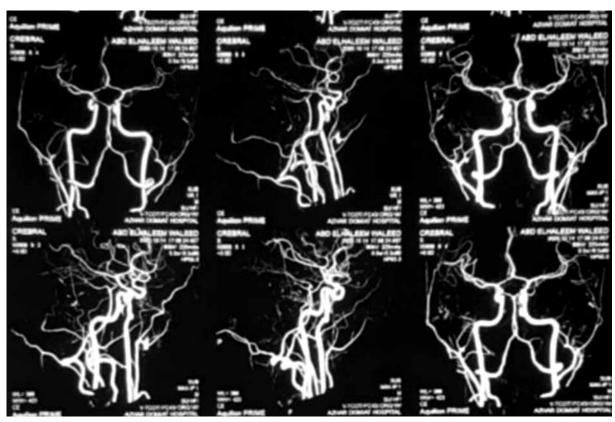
Computed tomography angiography (CTA) shows no detected abnormalities.
